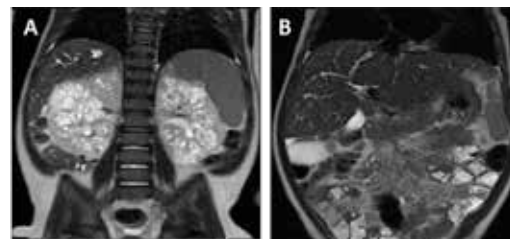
Coronal T2-weighted kidney (A) and liver (B) images from a 2-year-old patient with ARPKD. Note the substantial hyperintense renal cysts and expanded liver bile ducts typical of ARPKD kidney and liver disease.
